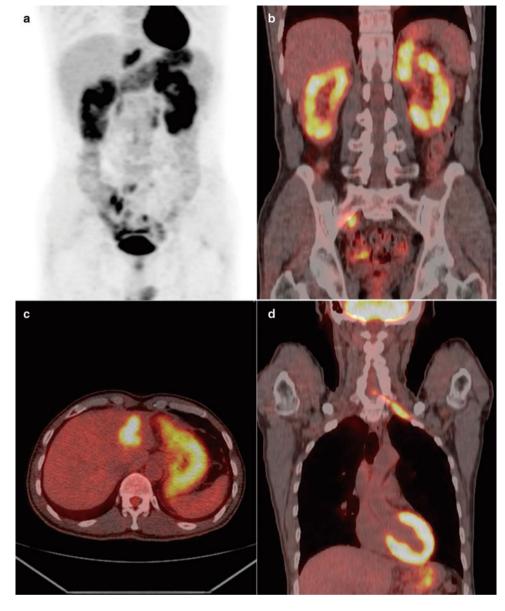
FDG accumulation in interstitial nephritis (a, b) and liver pseudotumor (c). FDG accumulated clearly in the nerve plexus (d). (a) Maximum-intensity projection image, (b–d) PET-CT fusion images
